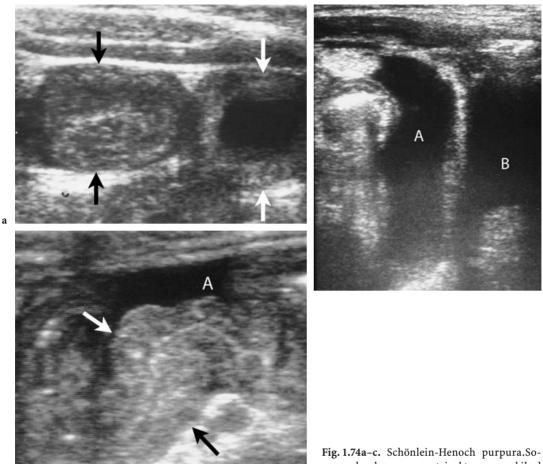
Schönlein-Henoch purpura.Sonography shows symmetrical transmural ileal bowel wall thickening and ill-defined wall layers (*arrows*). Anechoic ascites (*A*). *B*, bladder
